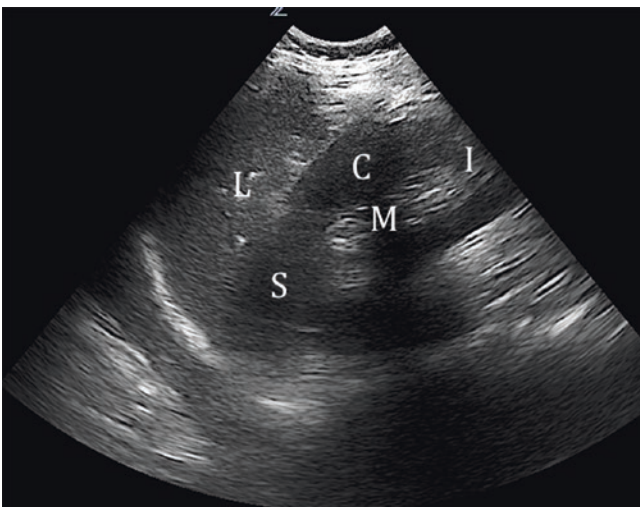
Ultrasound image of the right kidney in the longitudinal plane. This view should demonstrate the superior (S) and inferior (I) poles, cortex (C), and medulla (M) of the kidney. The liver (L) can be seen superior to the kidney. See Video 28.1. (Image courtesy of Stephen Alerhand.)
